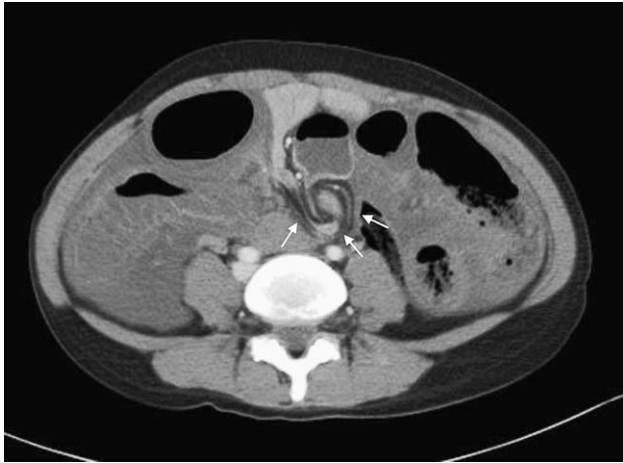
(a) Contrast-enhanced CT scan (axial view) shows a dilated loop of intestine with a surrounding whirl (small white arrows).
